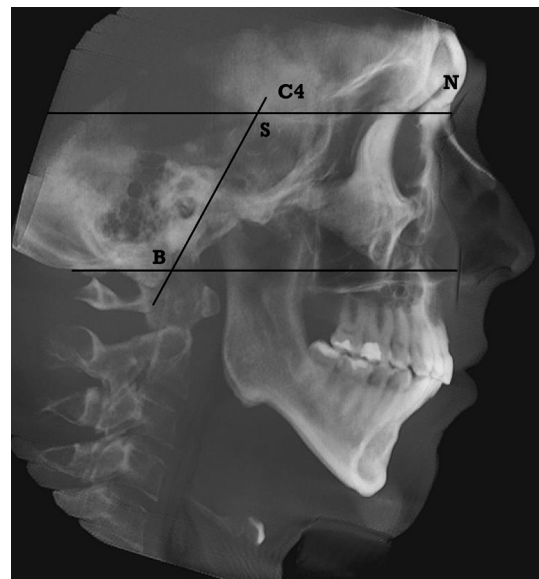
Cephalometric X-ray with indication of basion-sella-nasion angle and “lines” investigated to evaluate position of odontoid and occipital hole. Basion-sella-nasion – Ba–S–Na-angle, also called sphenoidal angle is related to the vertical growth of the skull base and it is under the control of the speno-occipital synchondrose. This suture brings the occipital hole in a lower position. The movements of the occipital and sphenoid bones are important as there must be an adjustment with a position tangent to the tip of the odontoid. The craniocervical junction and the hard palate orientations are dependent on the speno-occipital synchondrose and on its flexion. Placement of the anterior spinal spine, of the hard palate, of the naso-maxillary complex and the skeletal class will have an impact on the width and placement of the hard palate and the size of the upper airway.
